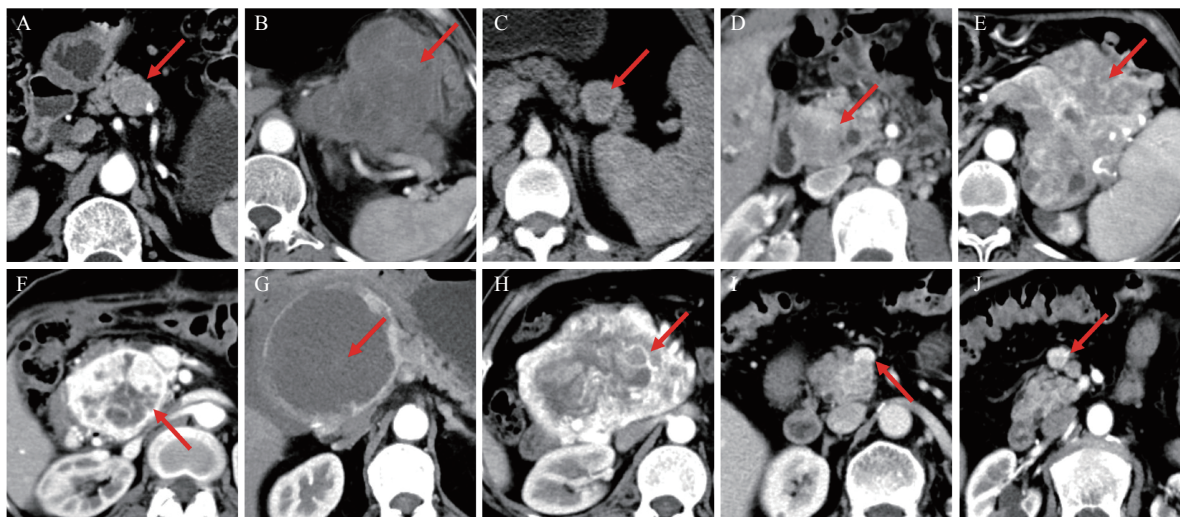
The imaging features of pancreatic neuroendocrine neoplasms on contrast-enhanced CT. A: Regular tumor shape and iso-density in arterial phase. B: Irregular tumor shape and hypo-density in arterial phase. C: Well-defined tumor margin. D: Ill-defined tumor margin. E: Heterogeneous enhancement. F: Edge enhancement. G: Cystic or necrotic components. H: Intratumoral blood vessels. I: Vascular invasion. J: Lymph node metastases. CT: computed tomography.
